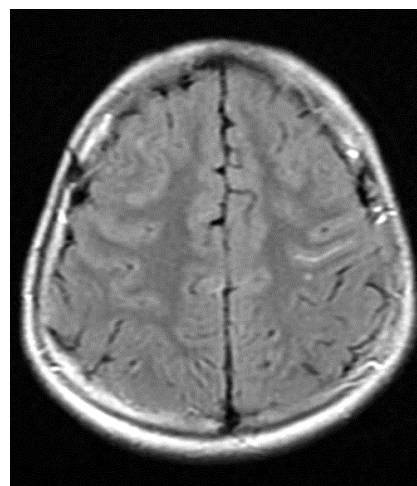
An initial brain MRI showed mild signal abnormality in some cerebral sulci.
